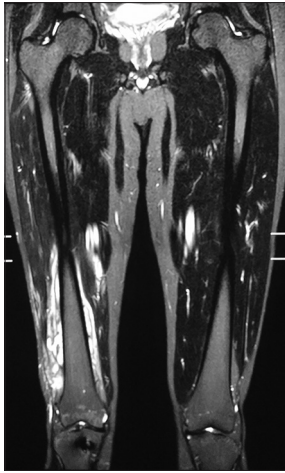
(Case B4) Magnetic resonance imaging showing thigh abscess
